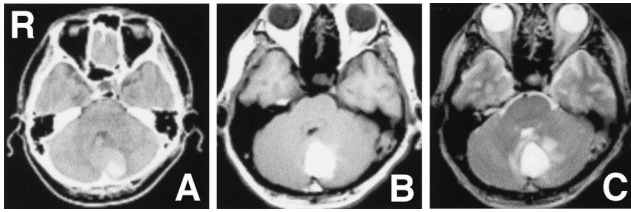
Computed tomography scan (A), and T₁-weighted (B) and T₂-weighted magnetic resonance images (C) showing a subacute hematoma in the cerebellum.
